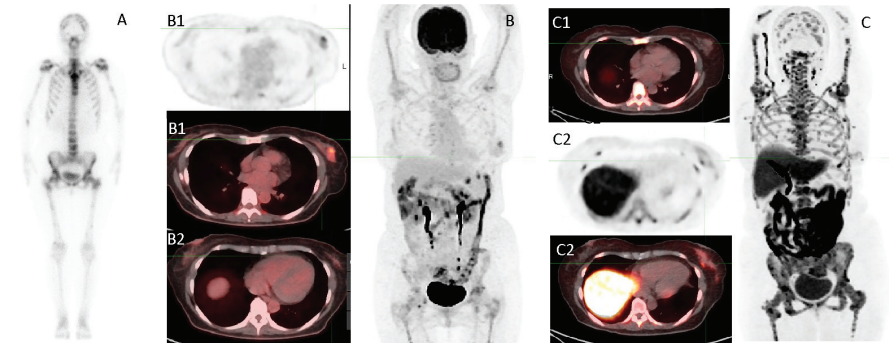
A patient presented with newly diagnosed metastatic low-ER-expression left-breast-invasive ductal carcinoma (IDC) ER+ 1%, PR+ 1%, ki67 30%, HER2-negative. An iliac bone biopsy demonstrated high ER expression (ER+ 80%, PR-negative, Her 2-positive, Ki67 20%). (A) 99mTc-MDP bone scan was significant for diffuse metastatic disease with mild uptake. (B) [¹⁸F]FDG PET CT was obtained with abnormal uptake in the left breast IDC (B1). No significant uptake was noted in the bones. (C) - [¹⁸F]FES-PET/CT obtained 2 weeks later demonstrated no uptake in the biopsied breast lesion (C1) with suspicious uptake in a different breast lesion (C2) and diffuse bone uptake (C) consistent with known iliac biopsy. Patient started endocrine therapy.
